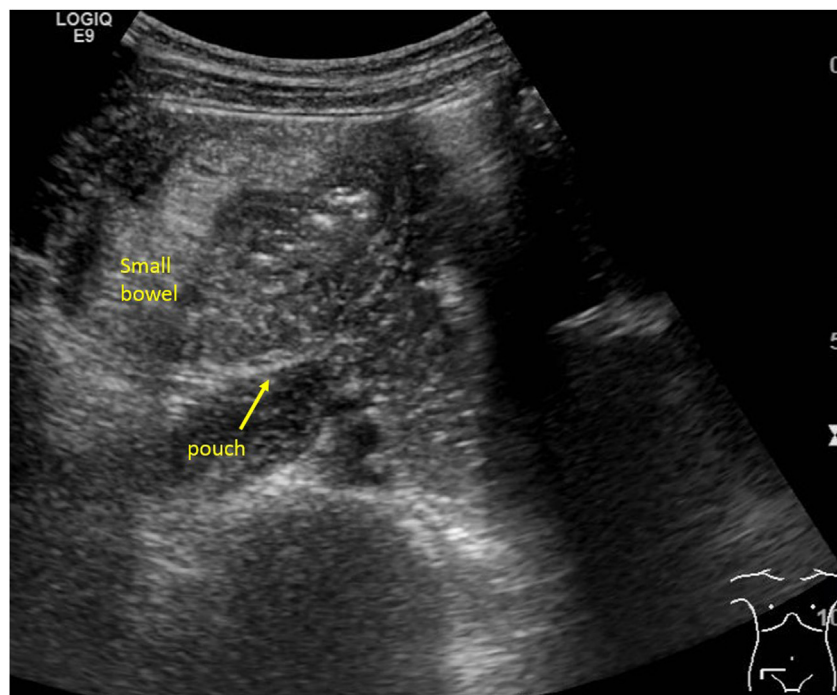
Abdominal sonography.
